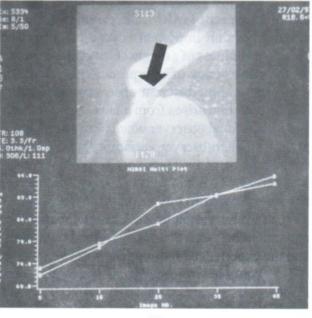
B. Contrast MRM with dynamic study showed a spiculated lesion (arrow) with type I signal time curve, classified as probably benign lesion (MRI score = 2)
